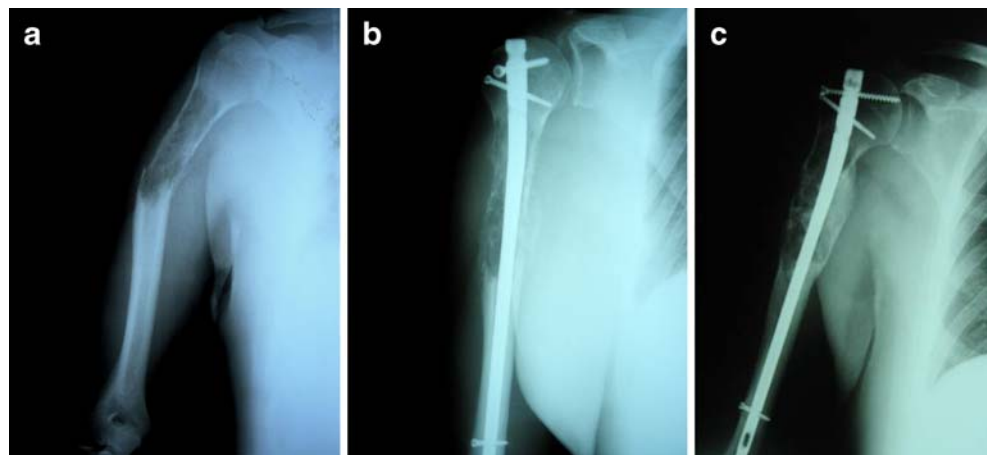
A 71-year-old man with lung cancer. a Preoperative radiograph shows pathological fracture at the middle third of the humerus. b Radiological result at 6 months after surgery
